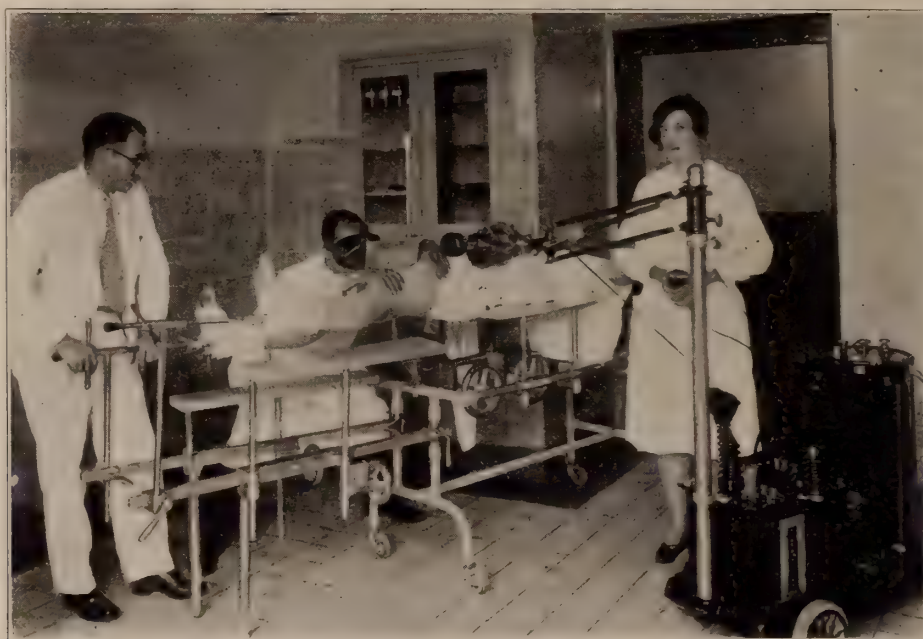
Method of reduction of fractured femur on McKenna fracture table, using a head fluoroscope and portable roentgen machine
